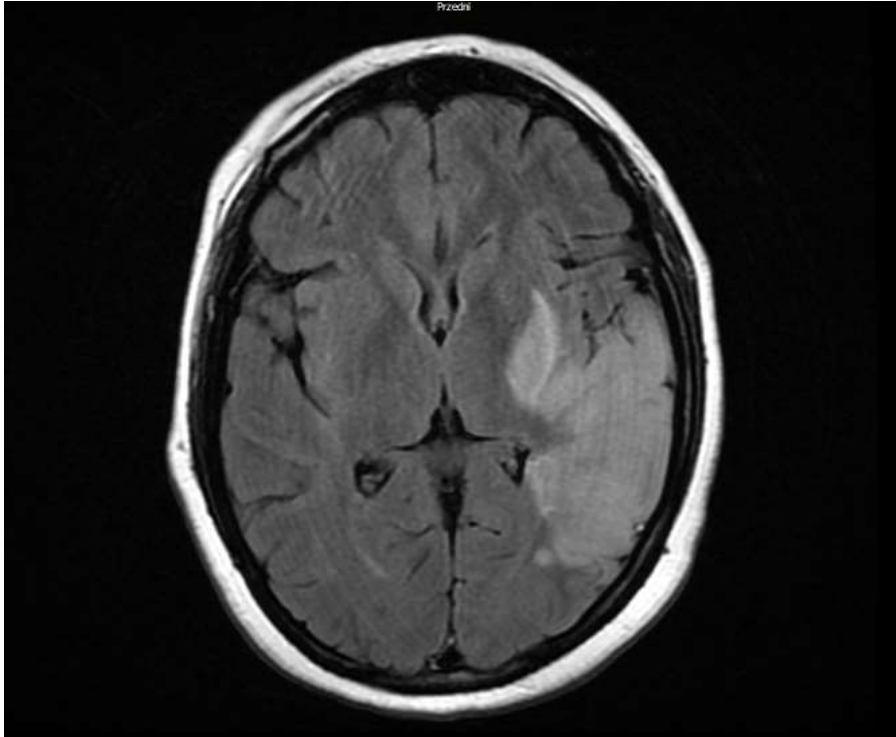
CT of the head (T2 FLAIR; fluid-attenuated inversion recovery) – within the temporal lobe / basal ganglia on the left side hyperintensive areas with diffusion restriction are visible (40x75 mm) [authors' material]
